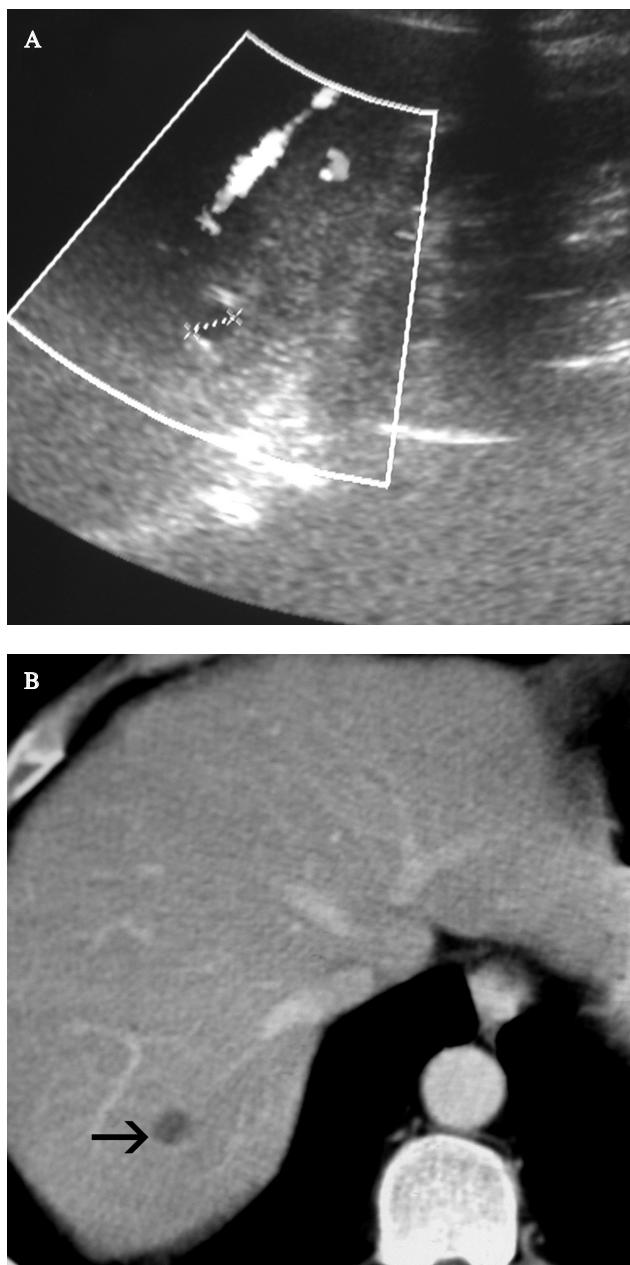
Ultrasonographic and B) CT scans before imatinib therapy show pure cystic and hypoattenuating metastatic lesions (0.8x0.9 cm) (arrows) in segment VII of the right liver lobe.
